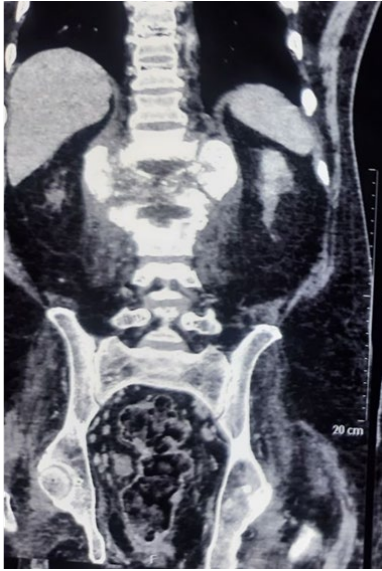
Coronal section of MRI LUMBO-SACRAL area showing Wagner et al. '6D's'.
